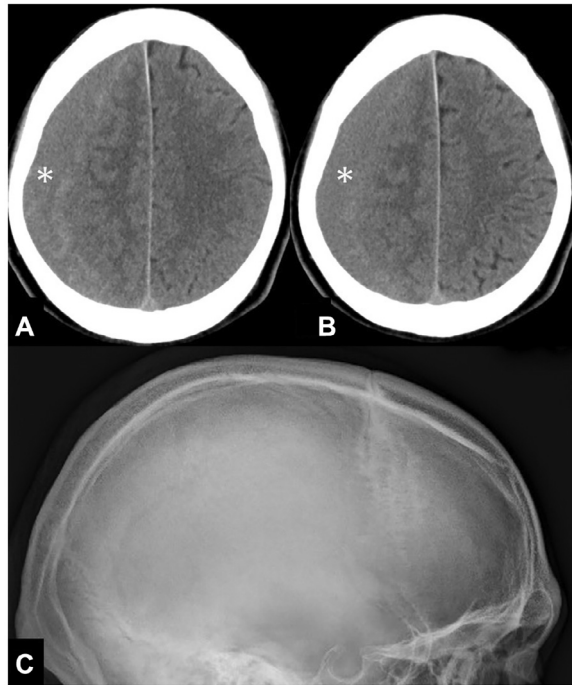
Contiguous images of axial computed tomography scans (A and B) and lateral view of cranial radiography (C) performed at presentation showing an isodense subdural hematoma in the right frontoparietal convexity (asterisk). Note that there is no fracture line found in the skull (C).
